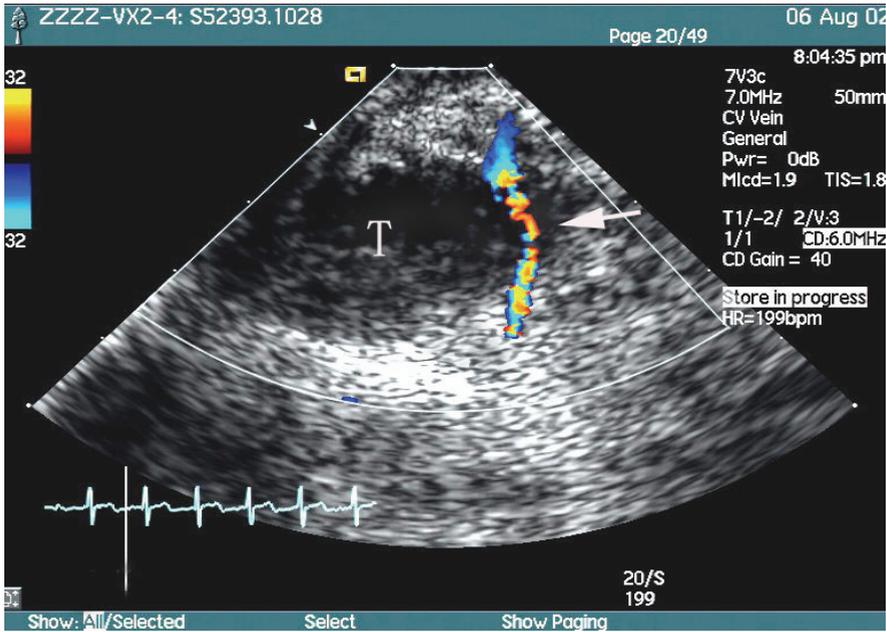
Mosaic and thread-like color Doppler flow signals were seen in SVC in a rabbit with SVCO by color Doppler ultrasonography. T: tumor
